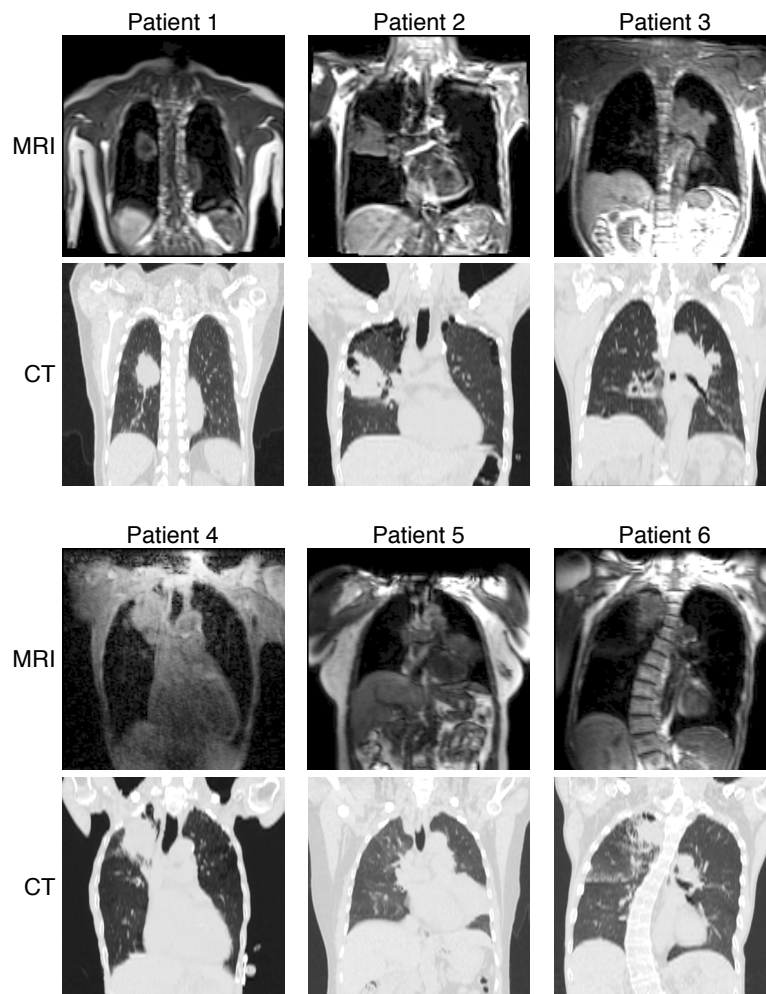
Sample images of 4D-MRI and 4D-CT of 6 patients
